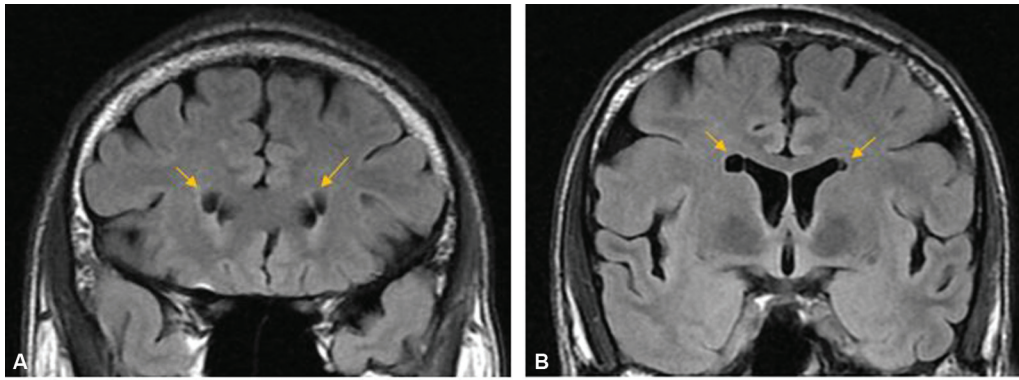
(A and B) Magnetic resonance imaging fluid-attenuated inversion recovery coronal images; arrows depicting periventricular hypointense cystic areas with no associated gliosis or volume loss, consistent with connatal cysts.
